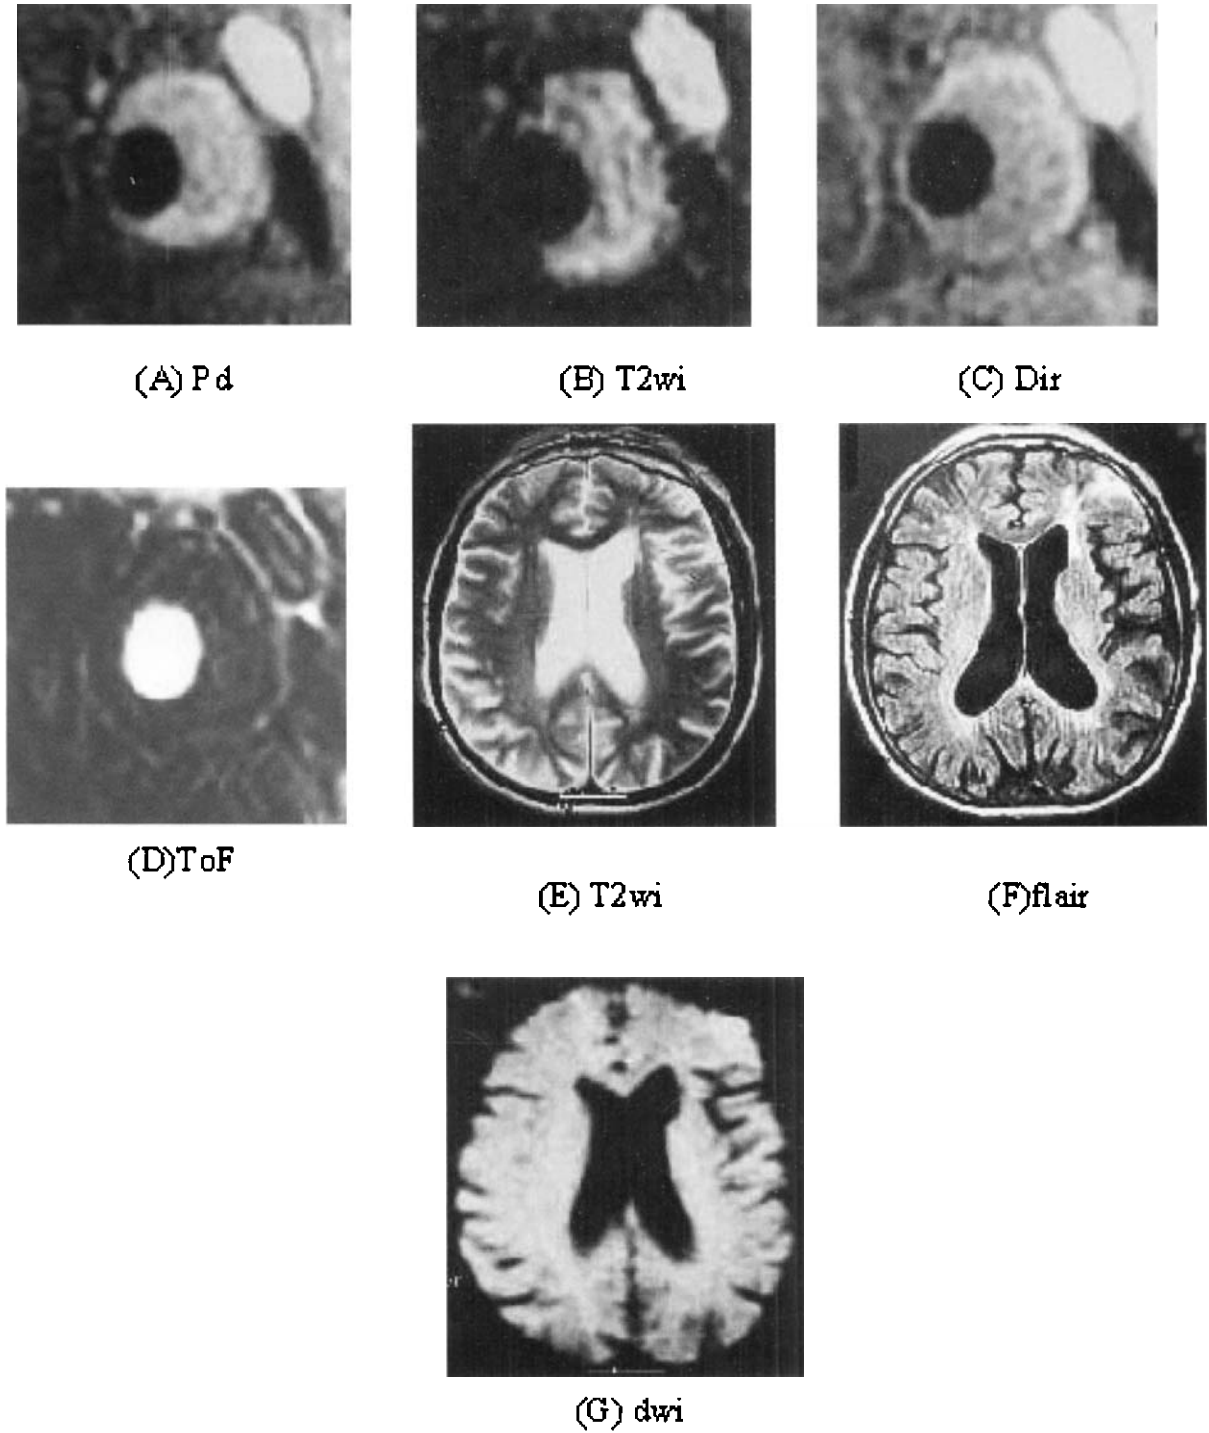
Severe stenosis involving the carotid bifurcation. Eccentric plaque is shown on PDWI (A), T2WI (B), DIR T1WI (C) and TOF (D) of the carotid artery. T2WI (E), fast FLAIR (F) and Diffusion weighted imaging (G) of the brain scan showed the ischemic lesions primarily located in the left frontal lobe.
